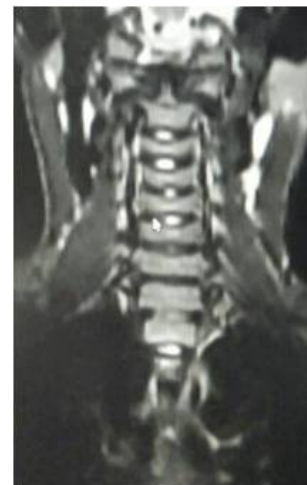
MRI image showing resolution of ligamental laxity with normal alignment of the atlanto-axial joint.
